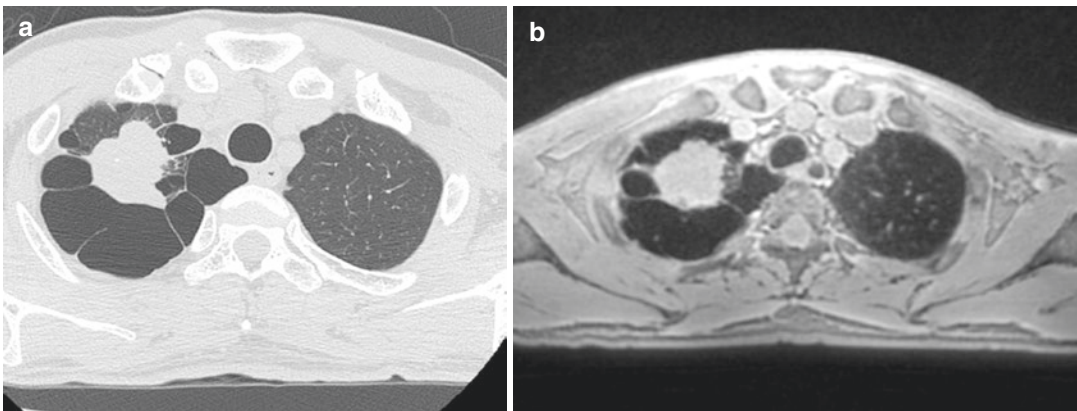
A 58-year-old male patient with invasive adenocarcinoma. (a) Thin-section CT shows invasive adenocarcinoma with notches and surrounding bullae. (b) Thin-section MR imaging with ultrashort TE less than
